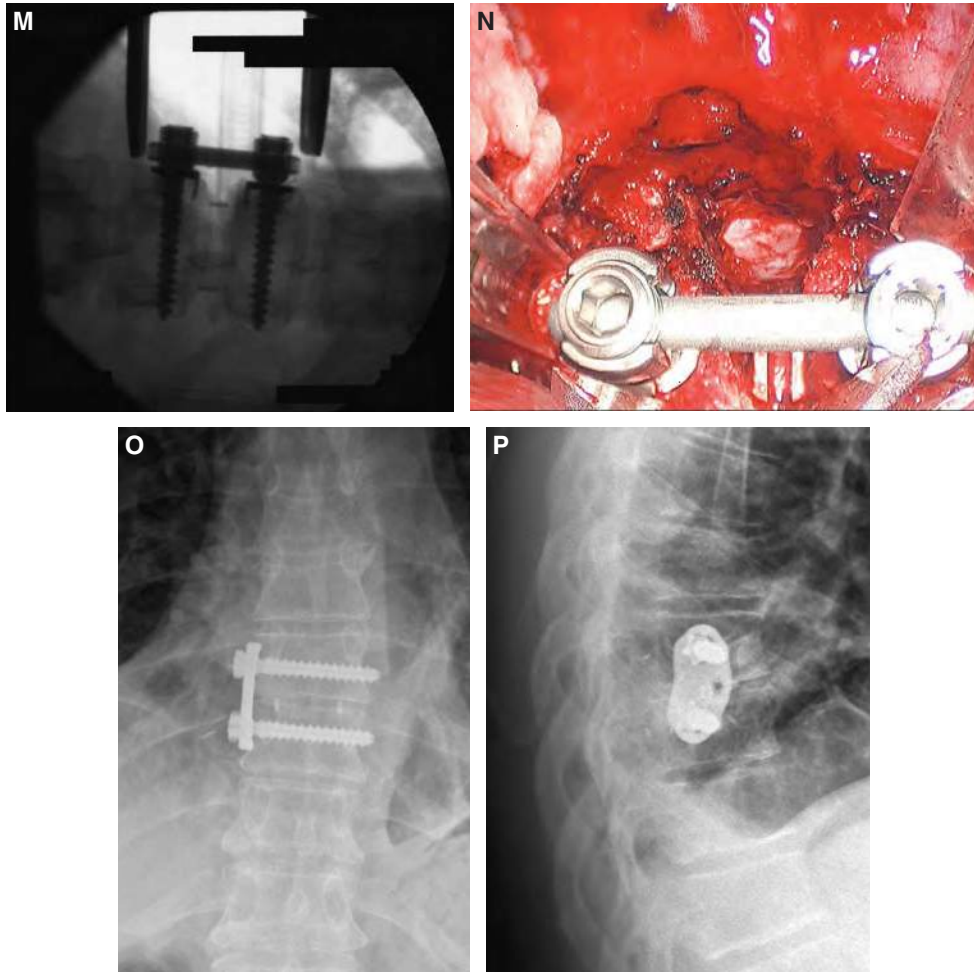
cont'd M and N, The interspace is further stabilized with a lateral single-rod construct, as evidenced on the radiographs and intraoperative views of the construct. O and P, AP and lateral radiographs showing thoracic decompression with fusion and use of lateral plating (XLP®, NuVasive, Inc.).
